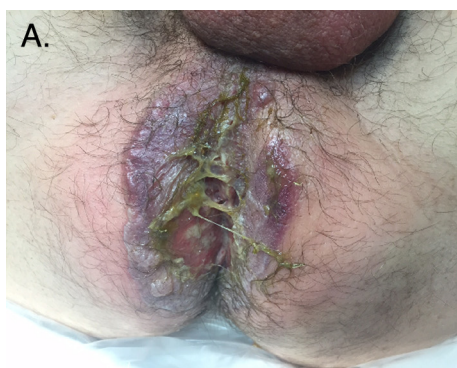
(A) Initial clinical manifestation consisting of bilateral perianal ecchymoses and perianal edema, which developed on postoperative day 7; (B) computed tomography of the pelvis repeated on postoperative day 7 revealing increased circumferential perianal inflammation and edema without abscess formation.
